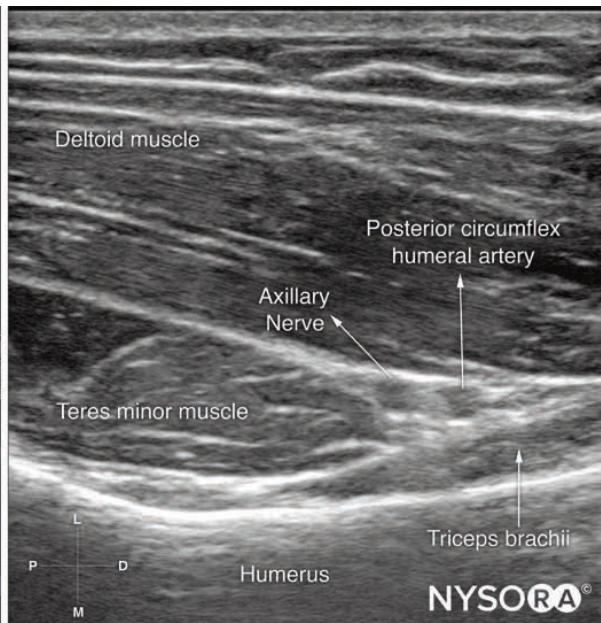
Transducer position and ideal ultrasound image for an axillary nerve block.
